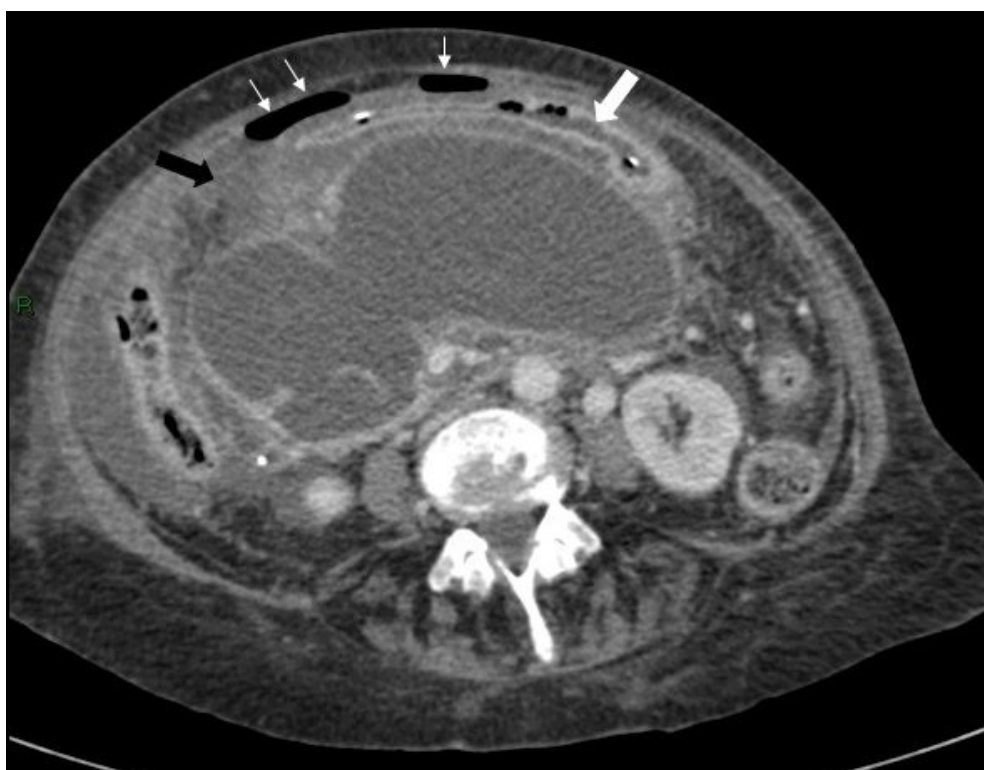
Initially, Axial CT scan showing the stomach containing a nasogastric tube anterior to the cyst (large white arrow), free air (small white arrows) and inflammatory changes in the soft tissues between the stomach/duodenum and the cyst (black arrow).
